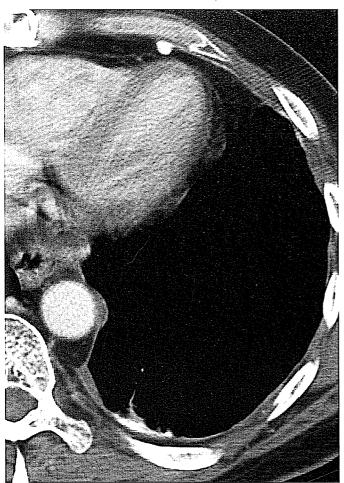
CT appearances following talc pleurodesis. CT in a patient who had aerosolized talc pleurodesis for a left-sided mesothelioma shows a nodular area of hyperattenuation along the left posterior chest wall. A further nodular collection of talc is seen anterior to the heart.
